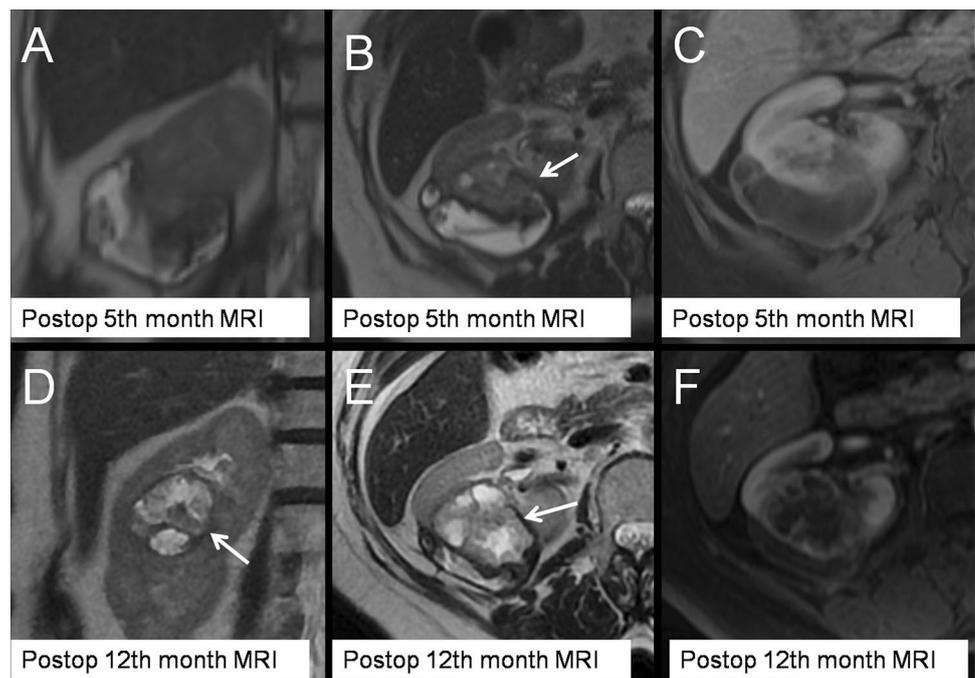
A 53-year-old man with partial nephrectomy due to clear cell-type RCC. A cellulose-based agent (Surgicel®) was used in the operation. In the first month follow-up MRI, there is a large MLL (bolster-related mass) at the operation site (upper pole) and PSFC
